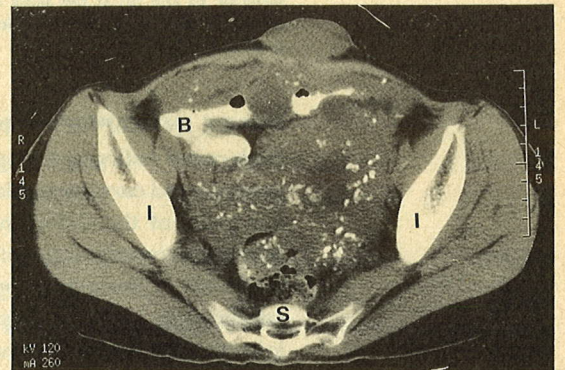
CT of the midpelvis (no contrast).
